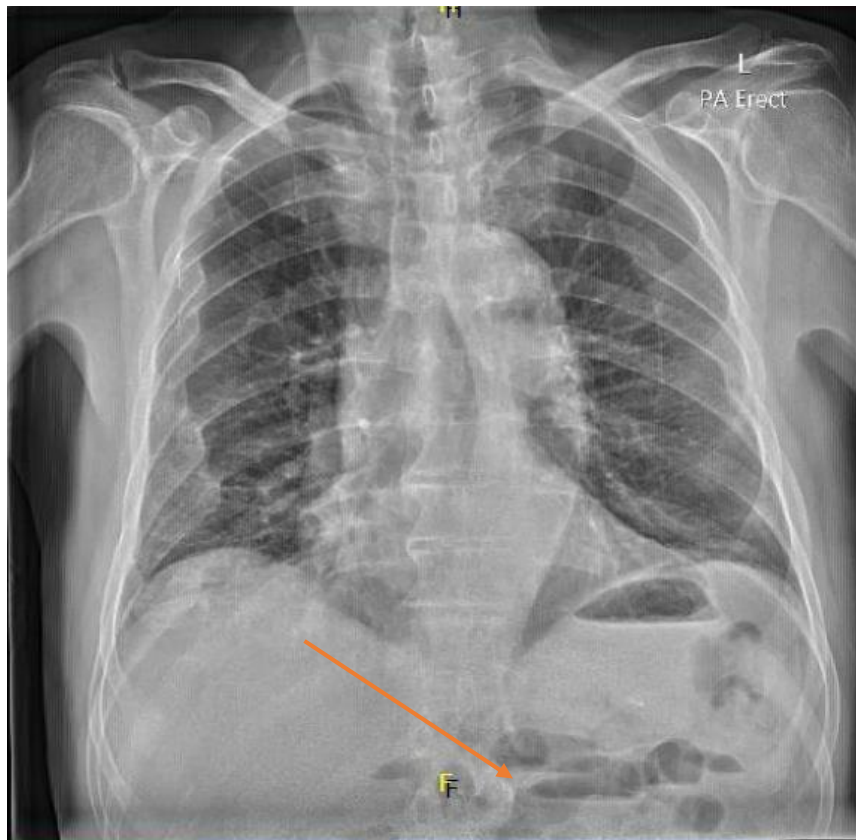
Chest x-ray displaying multiple air fluid levels
